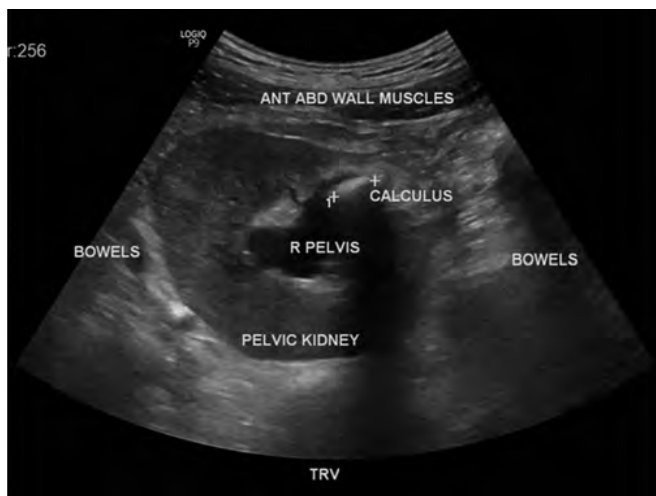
Ultrasound image of the pelvic kidney with adjacent structures.
